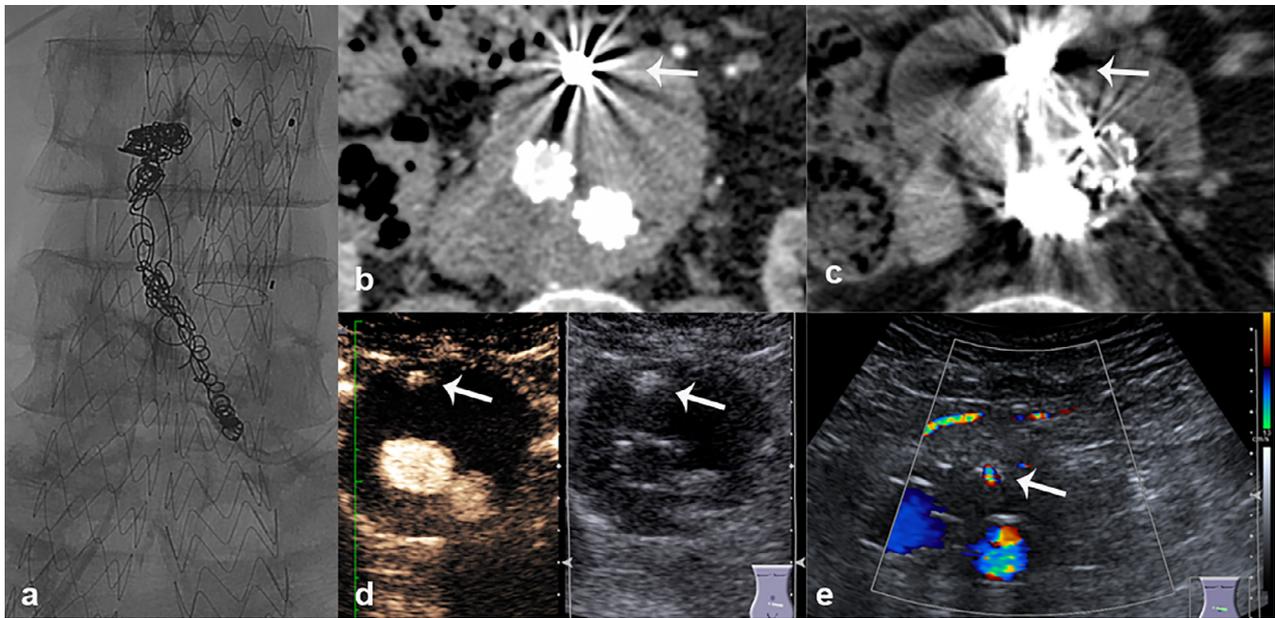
Artifacts caused by embolization material (*arrow*) in contrast-enhanced ultrasound (CEUS) in comparison with computed tomography angiography (CTA). (a) Fluoroscopy after embolization of the inferior mesenteric artery for treatment of endoleak II after endovascular aortic repair. (b,c) Postinterventional assessment of an abdominal aortic aneurysm with CTA is greatly reduced because of the beam-hardening artifacts by coils and Onyx, potentially obscuring persisting endoleaks. (d) The impact of embolization material on CEUS is less marked, allowing better assessment of the aneurysm sac and stent grafts. Embolization material presents as a local hyperechoic artifact in CEUS, occasionally correlating with reverberation in B-mode sonography. (e) Twinkling artifacts (*arrow*) on embolization material in color-coded duplex sonography.
